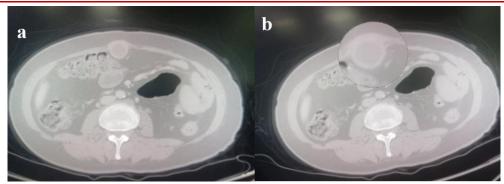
Axial cut CT scan at umbilical level. a, b) oval shape gallstone in the peritoneal cavity attached to the abdominal wall below the umbilical region
